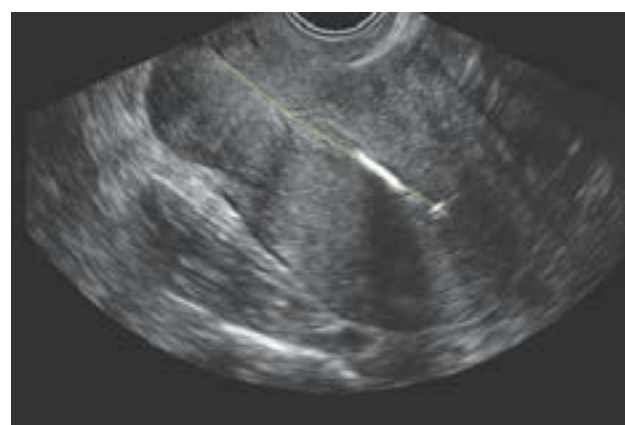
woman with axially positioned uterus. Ultrasound image shows cervix and body of uterus are in same axis as ultrasound beam
